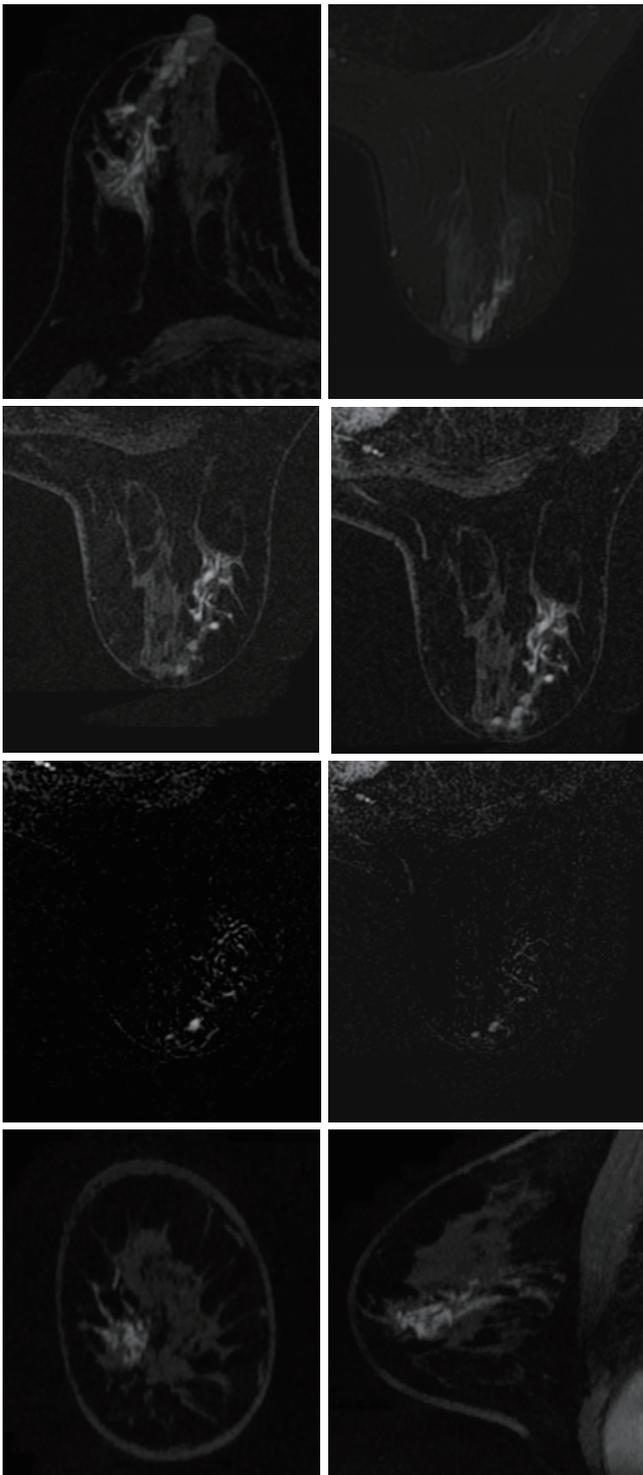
Multiple stippled lesions. Stippled enhancements are detected during the arterial phase, with non-specific morphological features. Ten minutes after injection of the contrast agent, these enhancements were “lost” into the enhancing surrounding breast parenchyma. BI-RADS-MRI category 3 is considered. F6-30.
